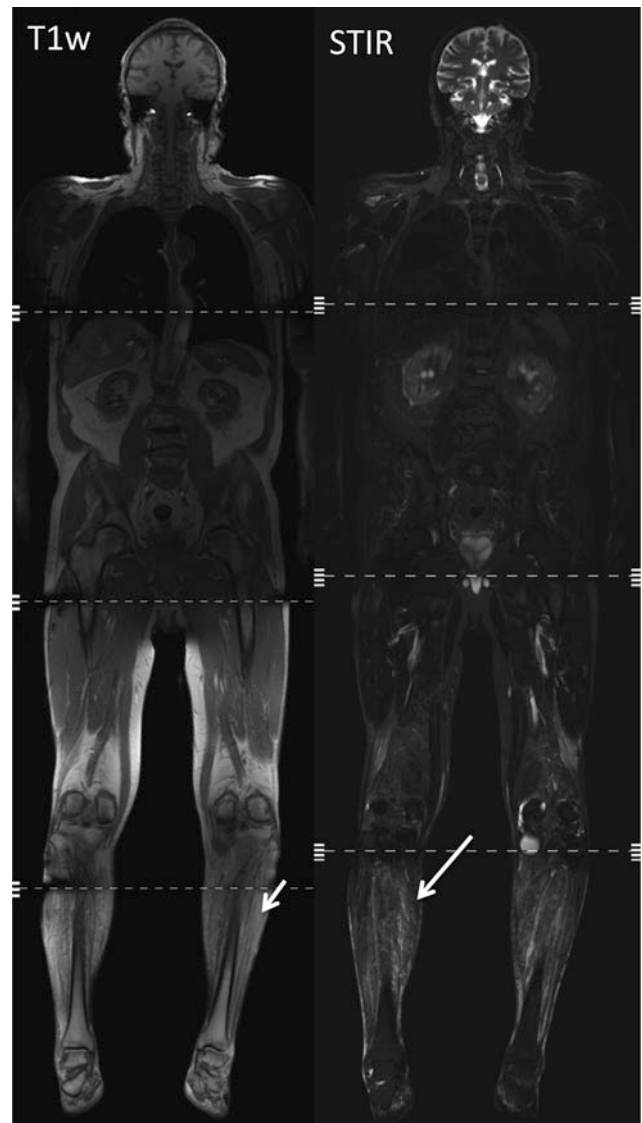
Secondary muscular changes of a 75-year-old male patient suffering from chronic inflammatory demyelinating polyneuropathy (CIDP); images post immunosuppressive treatment. Besides fatty degeneration of the muscles of the calves in T1w (*short arrow*) WB MRI depicts additional muscle edema as a sign of active disease (STIR, *long arrow*). Clinically, there were no signs of active inflammation (images courtesy of Prof. Dr. M.-A. Weber, Heidelberg)
